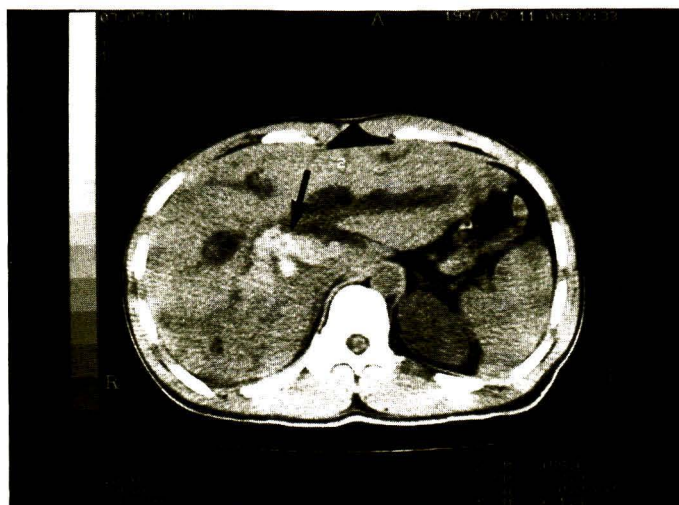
CT scan show dilated intrahepatic bile ducts containing hyperdensity lesions, representing blood clots (arrows).
